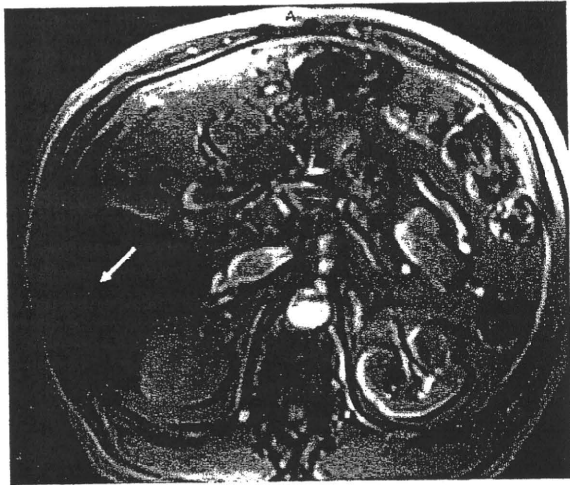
Magnetic resonance imaging using superparamagnetic iron oxide (Resovist). This enhanced imaging showed the largest nodule to be hyperintense relative to surrounding liver (arrow).
